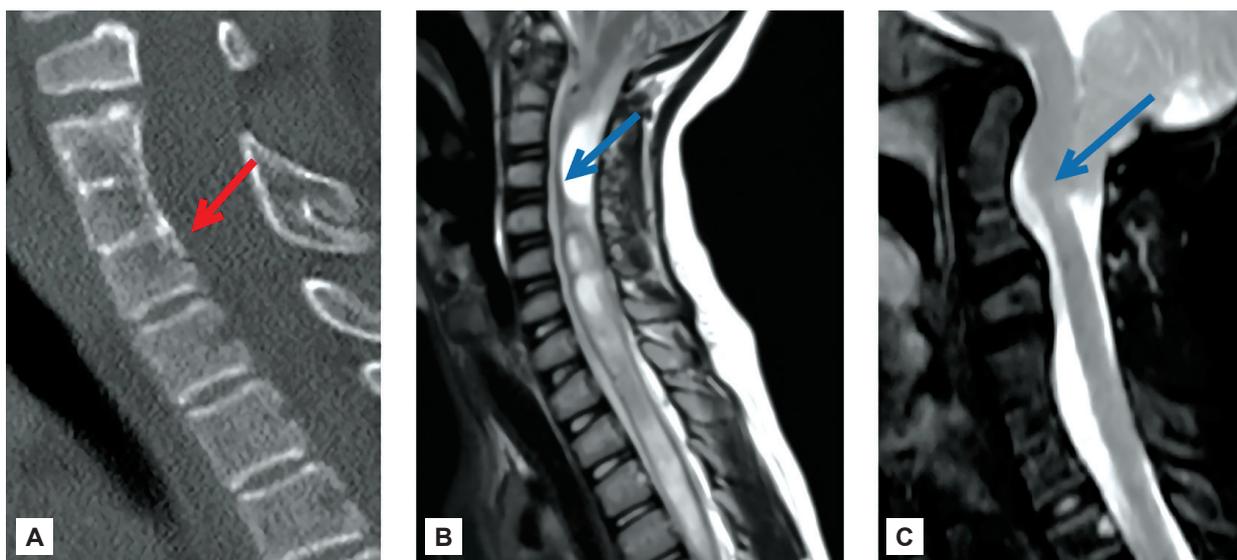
a) A T1-weighted MRI is shown. b) A T2-weighted image shows descent of the cerebellar tonsils, with syringomyelic cavities, syringus fluid, and associated strong suspicion of Klippel-Feil syndrome. c) The herniated cerebellar tonsils show compression of the cervical spinal cord, with syringomyelia
